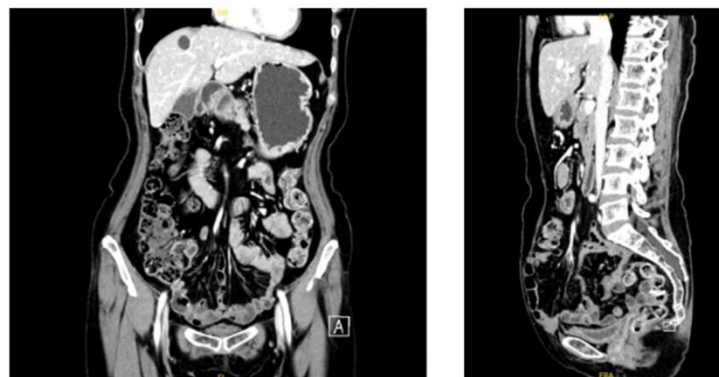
CT Imaging Performed in February 2025. No evidence of recurrence was observed.
